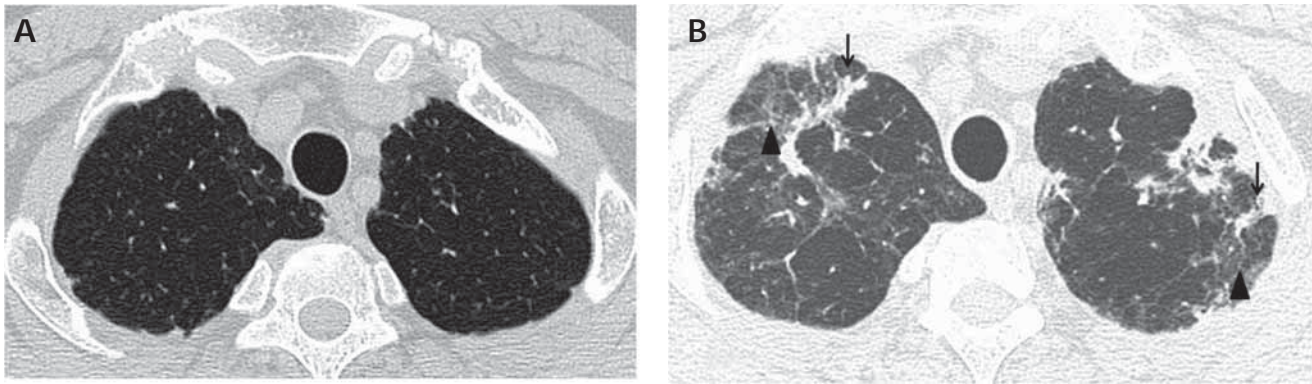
A, HRCT scan at the level of the upper lobes showing the normal lung parenchyma in the year 2005. B, HRCT scan from the same level in the year 2008 showing development of focal areas of fibrosis (arrows) and ground-glass opacities (arrowheads) in the follow-up period. HRCT indicates high-resolution computed tomography.
